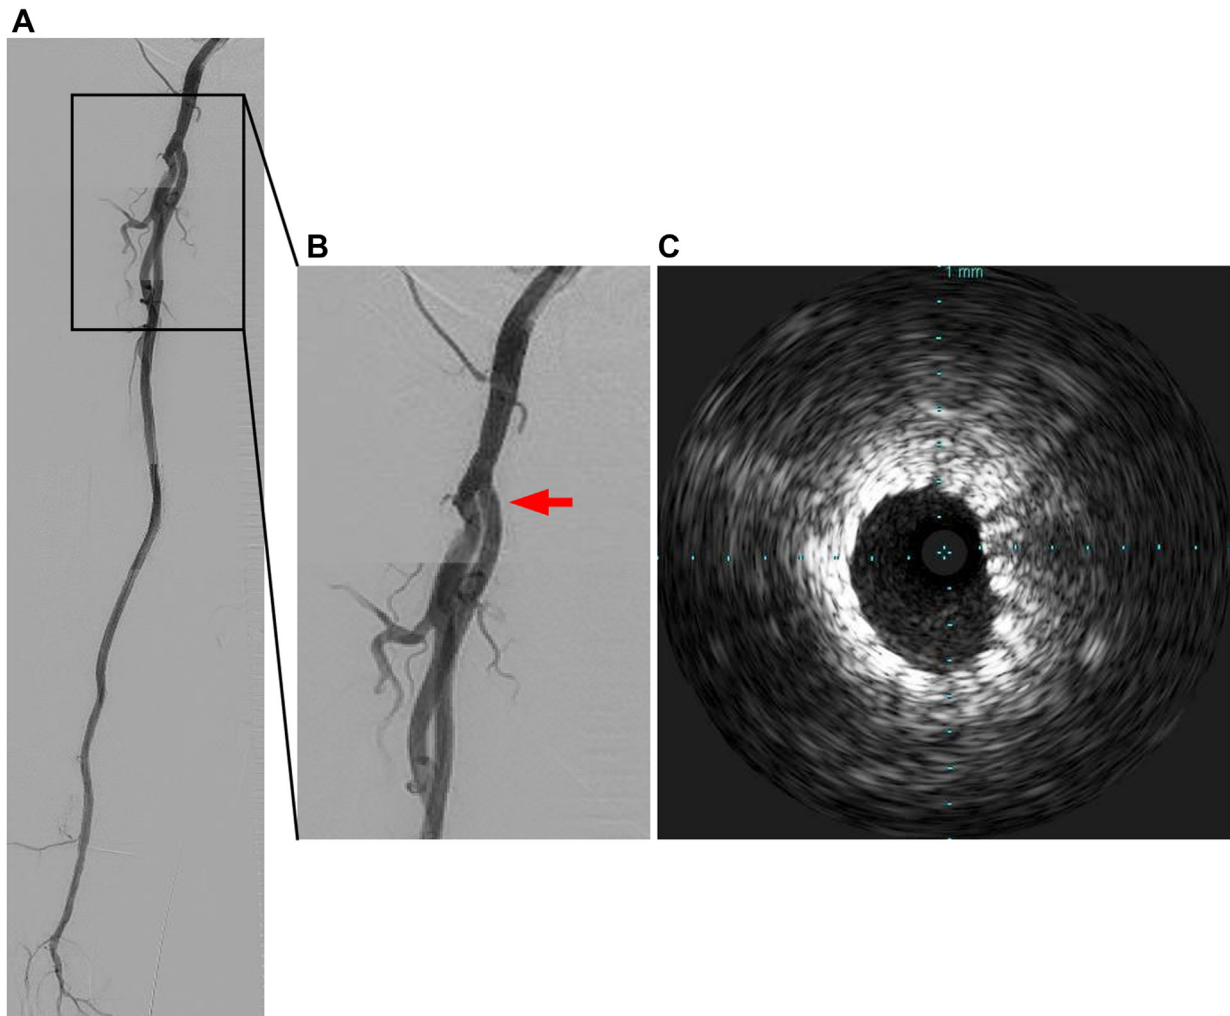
A, Final angiography showed a favorable flow in the superficial femoral artery (SFA). B, Angiography at the site of the plug protrusion (*red arrow*). It remained no stenosis. C, Intravascular ultrasound (IVUS) image at the *red arrow* (B). The stent was expanded enough.
